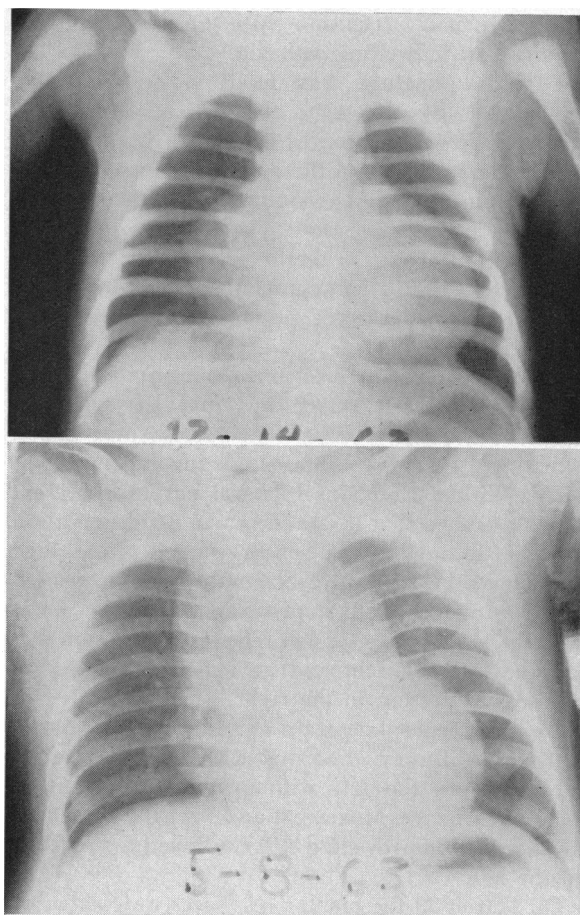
Preoperative (above) and postoperative (below) roentgenograms of chest (posterior-anterior projection).
